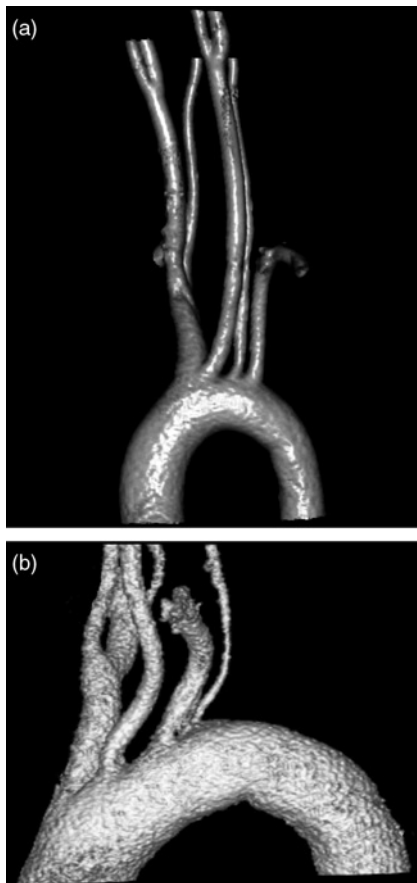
Left vertebral artery originating directly from the aortic arch. Contrast material assisted multidetector CT with the left vertebral artery originating proximal (a) of the left subclavian artery in a 19-year-old woman. (b) A rare case of the left vertebral artery originating distal of the left subclavian artery
